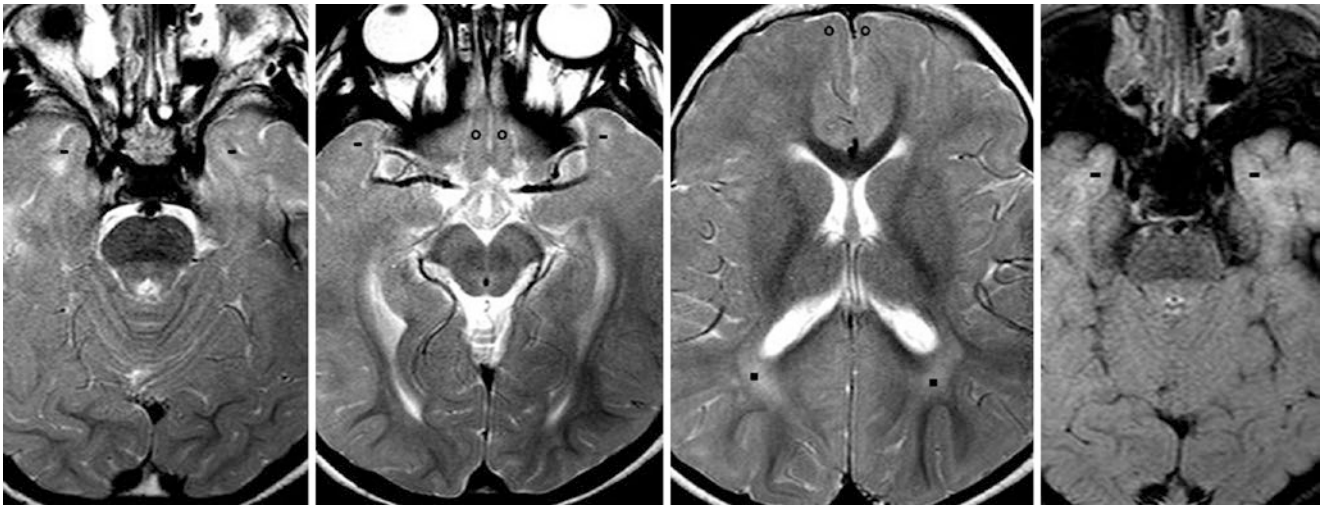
A developmentally normal 14.5-month-old with a head circumference that was not enlarging fast enough underwent a normal 3T MRI with SE T2WIs (left three images) and FLAIR (right). Note
